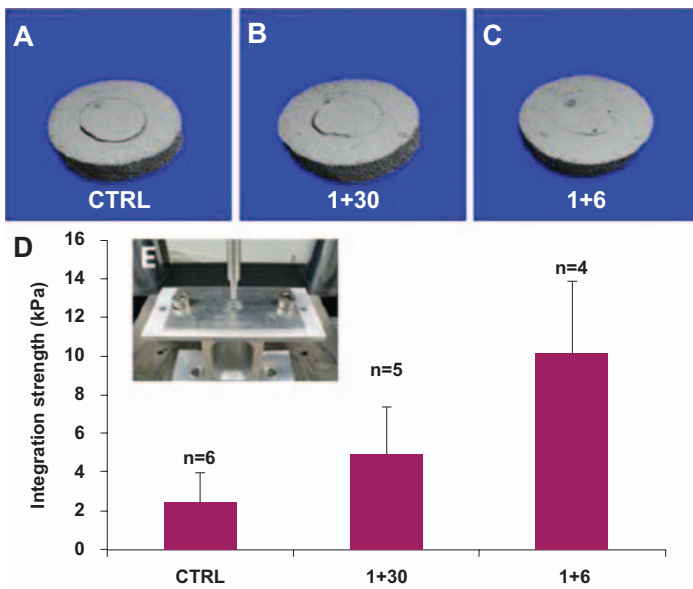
(A-C) Transverse cross sections of 3D μ CT reconstruction with different treatments. (D) Integration strength of the repaired defect showing increasing strength from the control to the 1+30 treatment to the 1+6 treatment. (E) Experimental setup of the push-out testing rig. Error bars are SEM.
